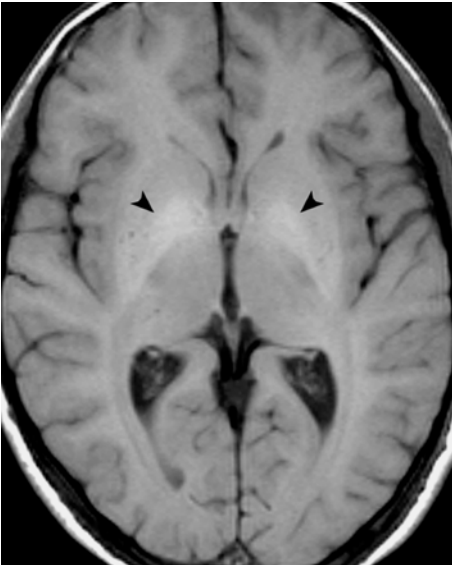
Signal abnormalities within the deep gray matter structures on the T1-weighted spin-echo images in Wilson disease. Ill-defined hyperintensities are seen within the globi pallidi bilaterally (*arrowheads*). Similar findings are not exclusive to Wilson disease and may also be seen in hepatic encephalopathies of other origin
